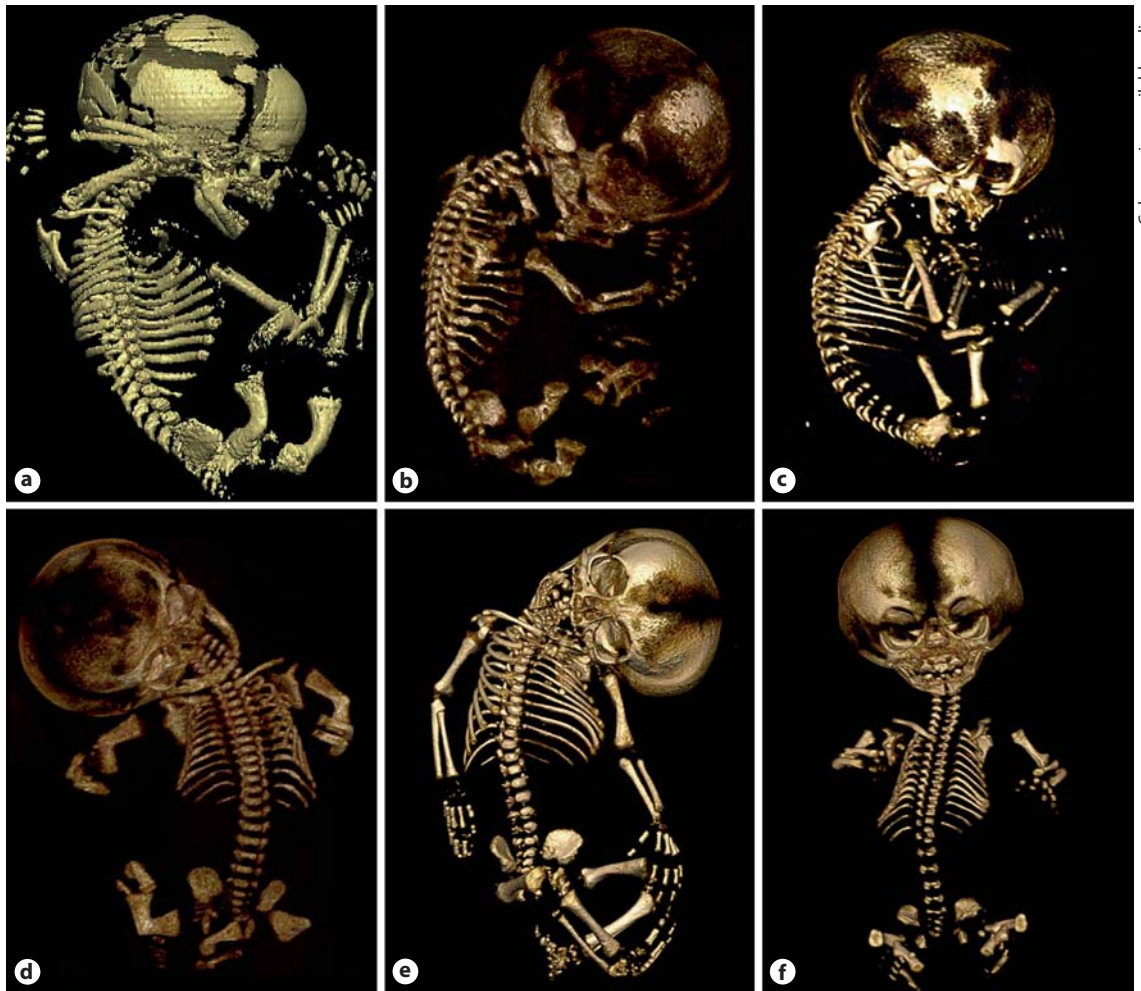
Prenatal 3D-CT reconstructions of the entire fetus. a Case 1. b Case 2. c Case 3. d Case 4. e Case 5. f Case 6.
